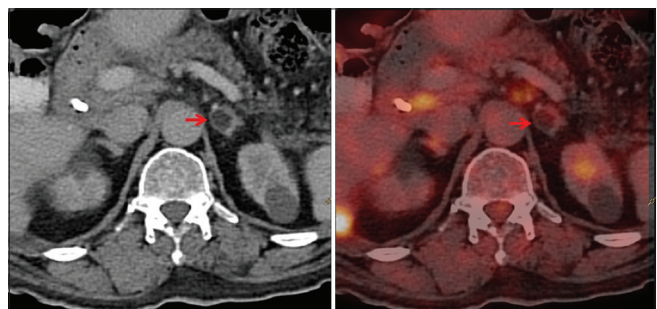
Adenoma. A 75-year-old male having carcinoma gallbladder with incidentally detected adrenal adenoma on fluorodeoxyglucose positron emission tomography-computed tomography (PET/CT). CT and corresponding PET/CT images showing a metabolically inactive homogenous well defined hypodense nodule in the left adrenal gland
